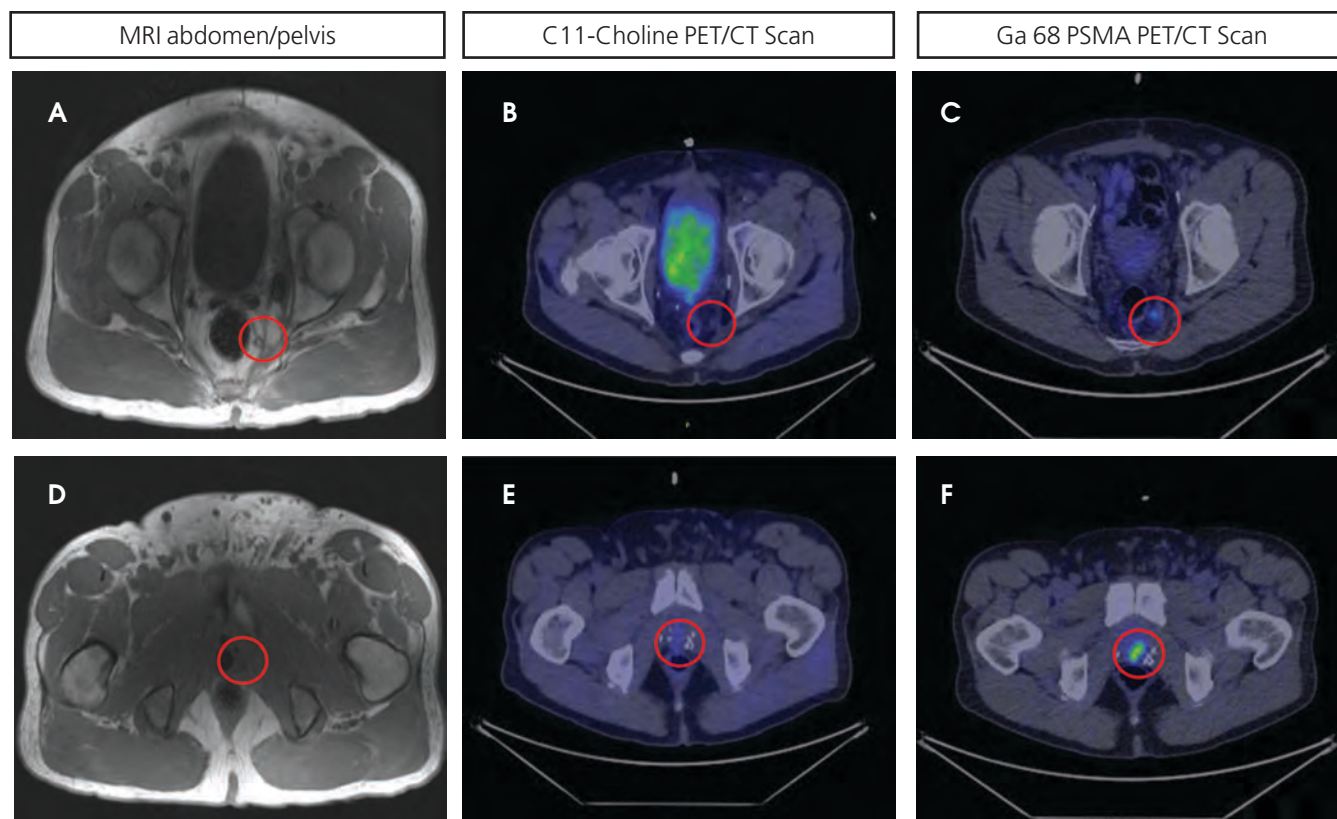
Comparison between MRI abdomen/pelvis, C-11 choline PET/CT and Ga68 PSMA PET/CT in detecting local recurrence.
